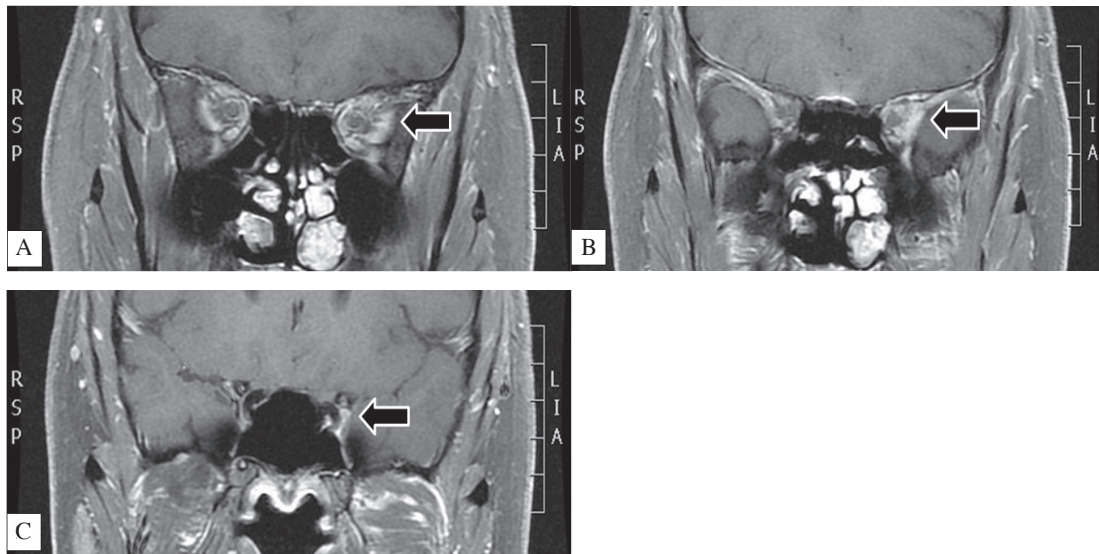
MRI at initial presentation with left 6th cranial nerve palsy. (A) and (B): MR coronal T1 weighted imaging post gadolinium with fat suppression. The arrows highlight an enhancing lesion in the perioptic and tendinous insertion of the left lateral rectus causing a fullness of the left orbital apex. (C): The arrow highlights the enhancing lesion extending to the left cavernous sinus.
